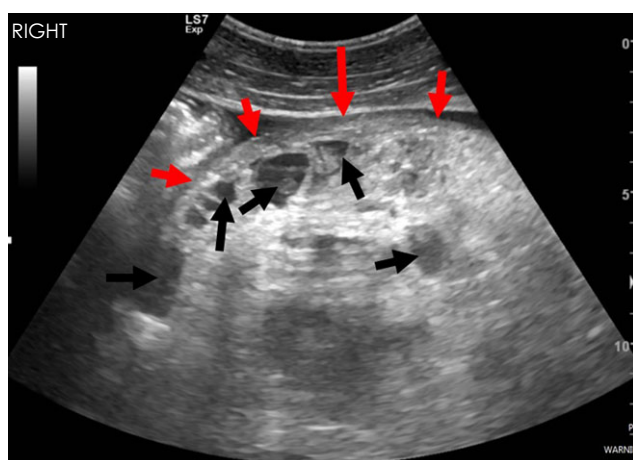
Case 1: Transcutaneous abdominal ultrasound image via the right paralumbar fossa. A large ovarian mass of mixed echogenicity with hypoechoic cystic structures (black arrows) adjacent to homogeneous soft tissue stroma consistent with a multilocular 'honeycomb' appearance typical of a GCT. Red arrows delineate the border of the mass.
